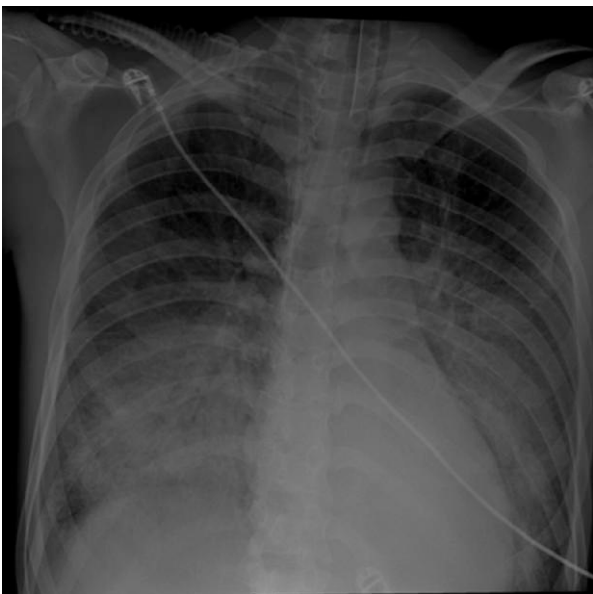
Thoracic X-ray. Thoracic X-ray showing bilateral pulmonary oedema.
